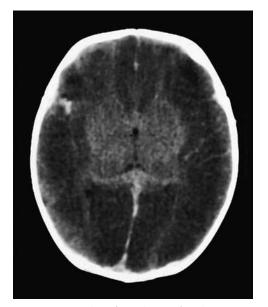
Hypoxic injury. This infant, who was found unresponsive in his crib, has a pattern of diffuse cortical hypodensity on CT scan, indicative of extensive cerebral infarction caused by hypoxia.
